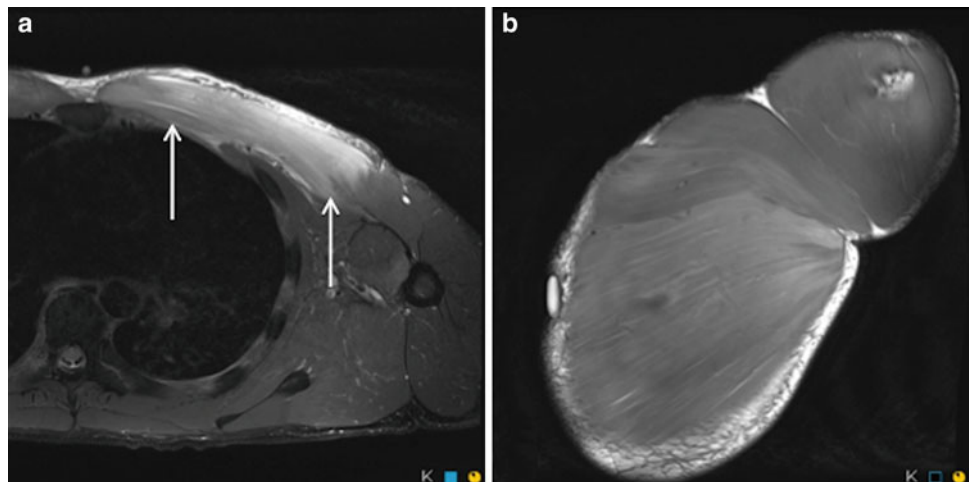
Axial (a) and coronal (b) proton density weighted MR images with fat saturation demonstrate the appearance of delayed onset muscle soreness in a pectoralis major muscle in a professional boxer after performing an excessive number of decline bench presses (arrows). Note the widespread muscle oedema, predominantly involving the sternal head, with associated muscle swelling
